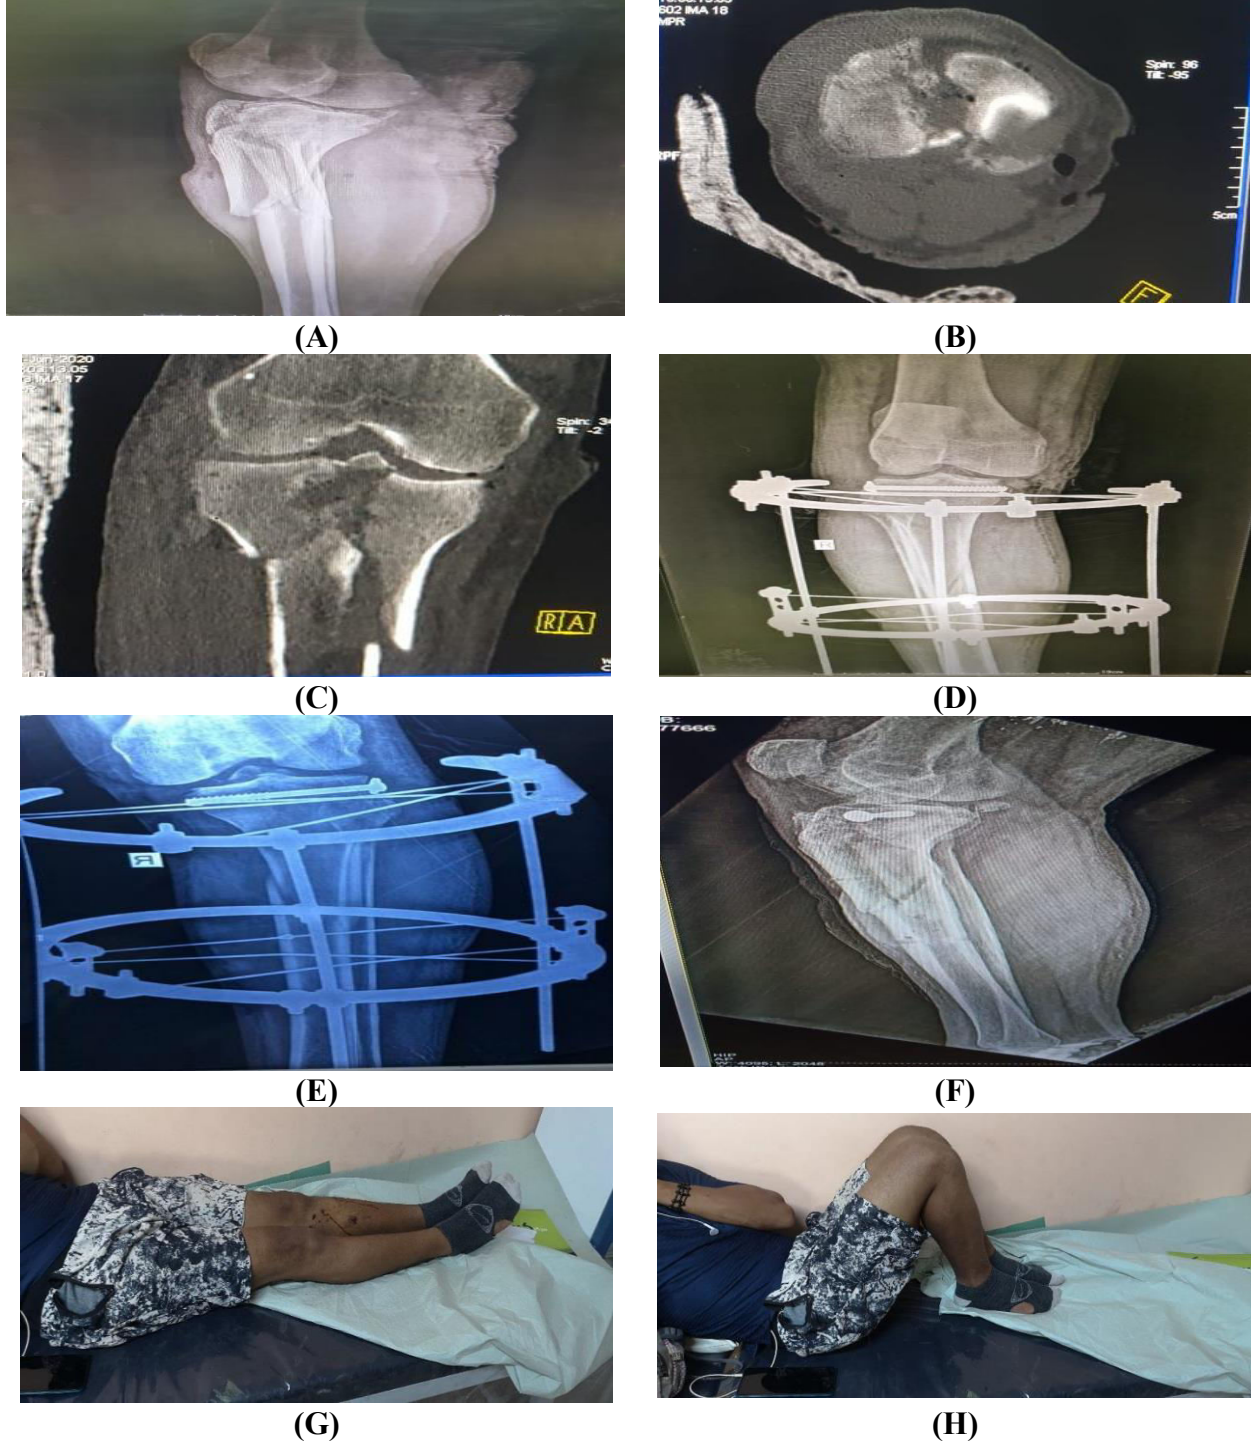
(A) Admission X-Ray, (B, C) CT cuts, (D) post x ray, (E) three months follow up x ray, (F) eight months follow up x ray and (G, H) range of motion
